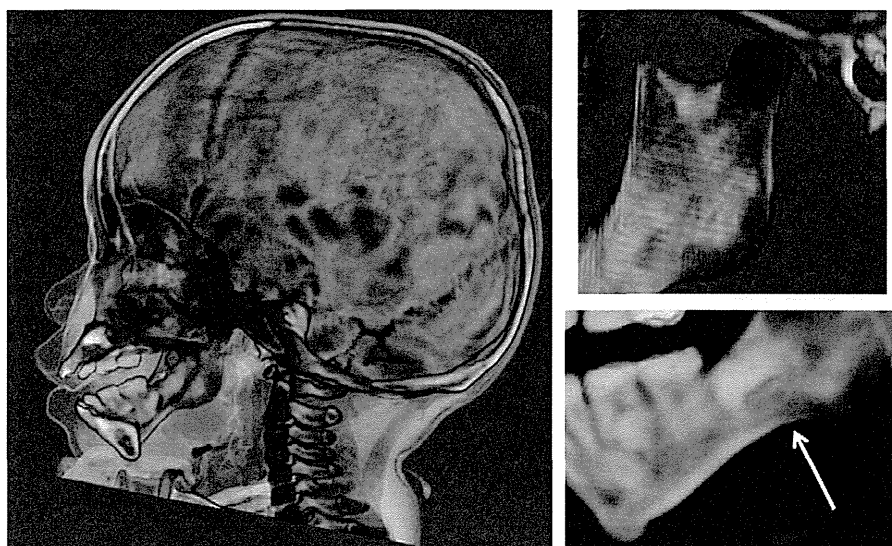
Multi-detector row computed tomography (MDCT)-synthesized lateral radiograph (left) and close view of mandible (right) of Patient 3 at age of 6 years. Note the macrocephalic skull with hypoplastic facial bones (left). Mandibular anomalies are also noted, characterized by thick and flat head of the condylar process, short condylar neck, narrow mandibular notch (right upper) and antegonial notching (right lower).
